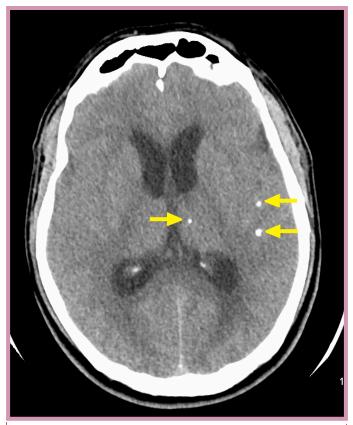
Representative image of CT head demonstrating multiple punctate foci of calcification (depicted by yellow arrows) with moderate ventriculomegaly. Findings concerning for neurocysticercosis with hydrocephalus.
